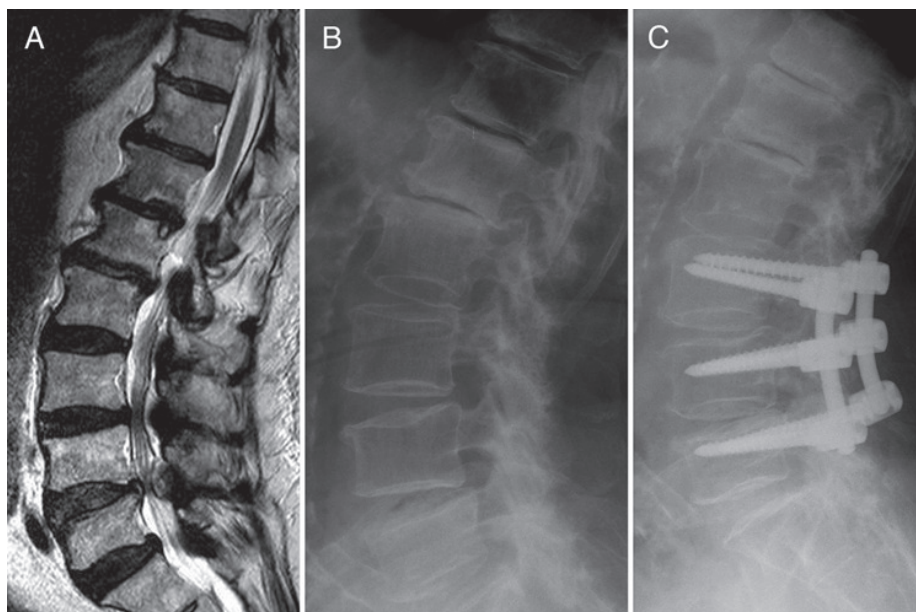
A and B: Preoperative MR imaging study (A) and preoperative radiograph (B) obtained in a 68-year-old man with spinal stenosis in L3–4 and L4–5. C: Postoperative radiograph obtained in the same patient after instrumentation with the Cosmic system at L3–4 and L4–5 and decompression.
